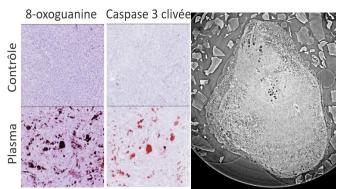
(a) IHC slices of CCA tumors, (b) Computed section of NSCLC tumor obtained by X-ray microtomography.
